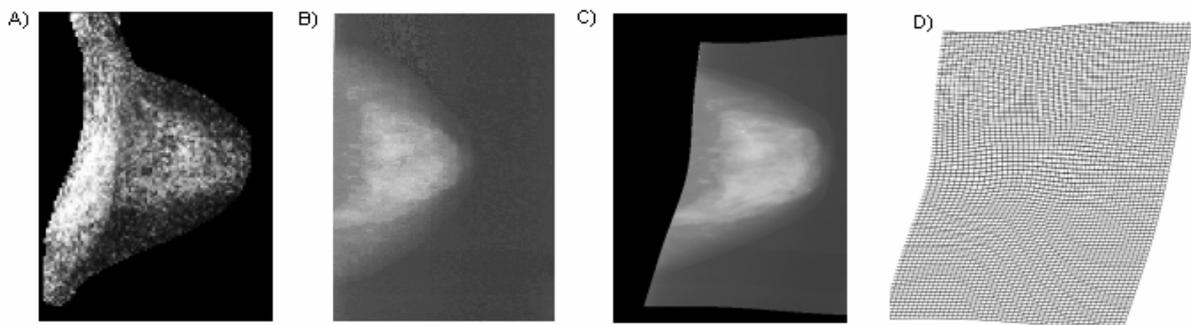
An example of registering a cranio-caudal mammogram A) to the corresponding MRI volume projection B). The resulting (cropped) deformation C) shows very good anatomical correspondence with the functional projection. D) shows the deformation of B) necessary to achieve the registration.
